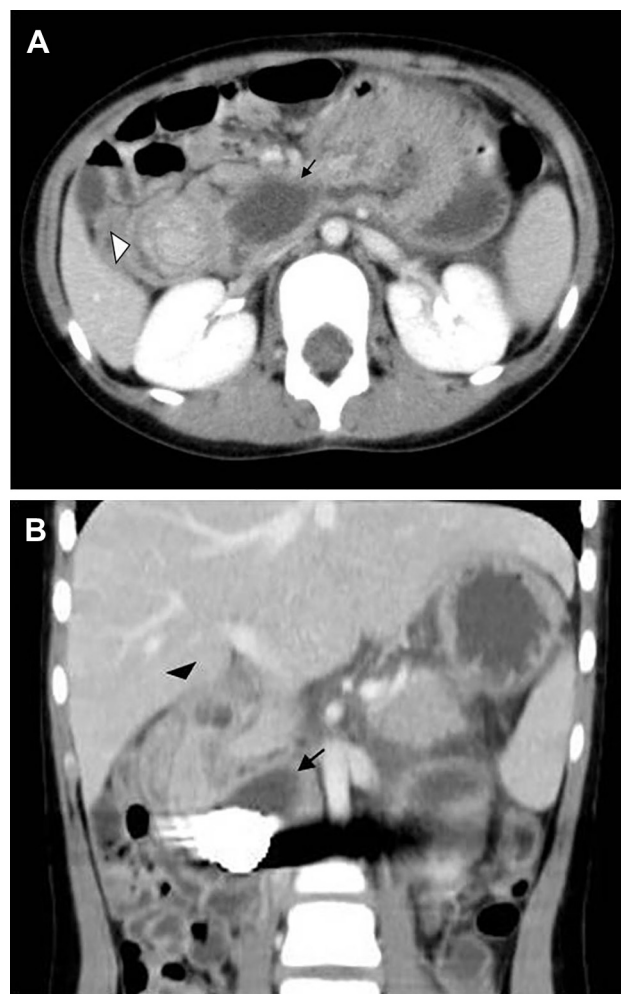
(A) Initial contrast computed tomography (computed tomography dose index 3.86 mGy) showing the "target" appearance in the region of the duodenum, which confirmed the diagnosis of duodenoduodenal intussusception (white arrowhead). The image shows a fluid-filled lesion that appeared to arise from the duodenum (black arrow). (B) Coronal multiplanar reformatted image showing the duodenoduodenal intussusception (arrowhead). The image also shows a fluid-filled lesion with a metallic artifact lying distally to it (black arrow).
